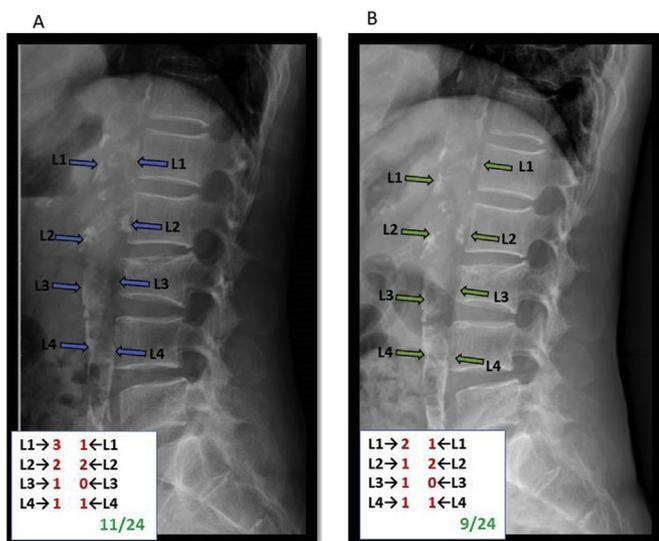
Lateral lumbar spine X-ray with images of calcification in the abdominal aorta of one patient in the study. The calcification scores of the abdominal aorta were 11/24 (A) before surgery and 9/24 (B) one year after parathyroidectomy.
